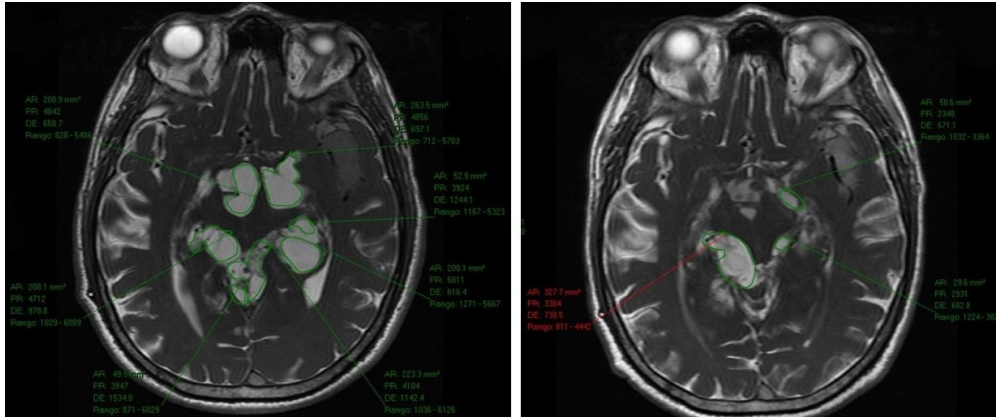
Example of volume determination in one axial level of FIESTA MRI (left: pre-treatment; Right: post-treatment)
